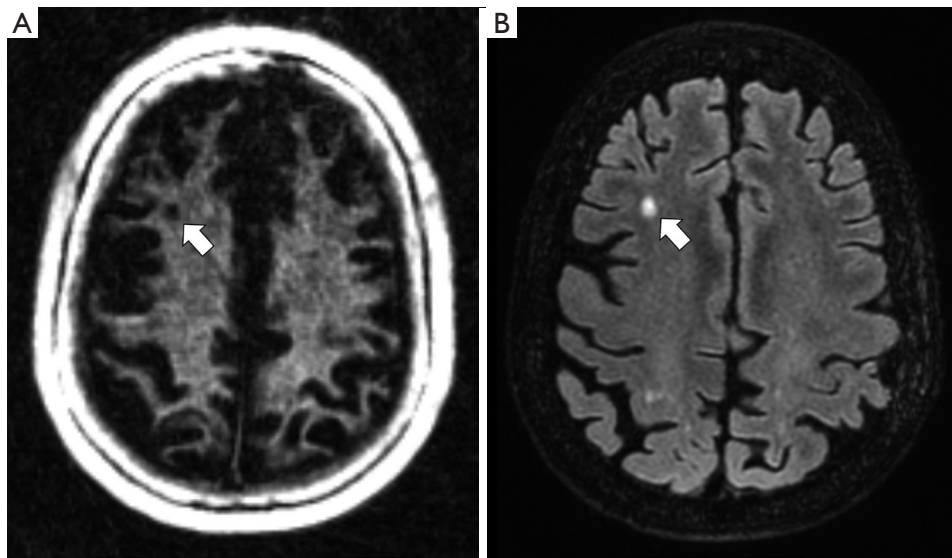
Whole brain image on 3D IR-UTE (A) and 3D FLAIR (B). A WML in the right frontal lobe is shown (white arrow). IR-UTE, inversion recovery ultrashort echo time; FLAIR, fluid-attenuated inversion recovery; WML, white matter lesion.
